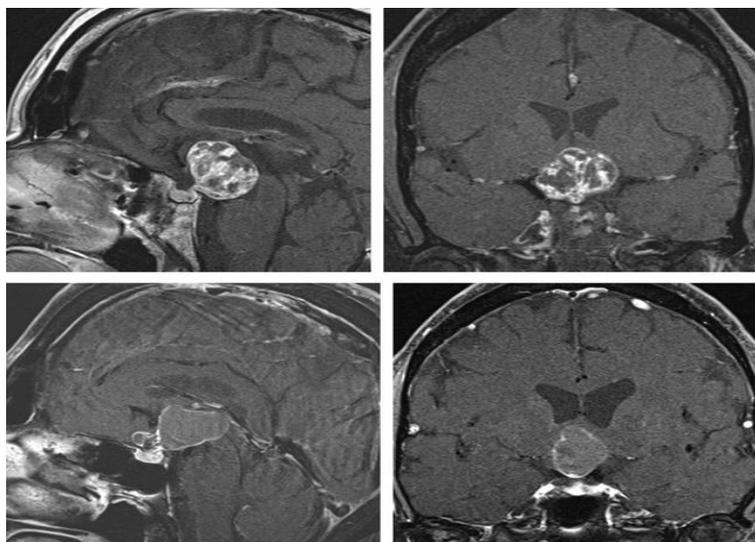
MRI Images of Craniopharyngioma with Solid (Upper) and Partially Cystic (Lower) Components
